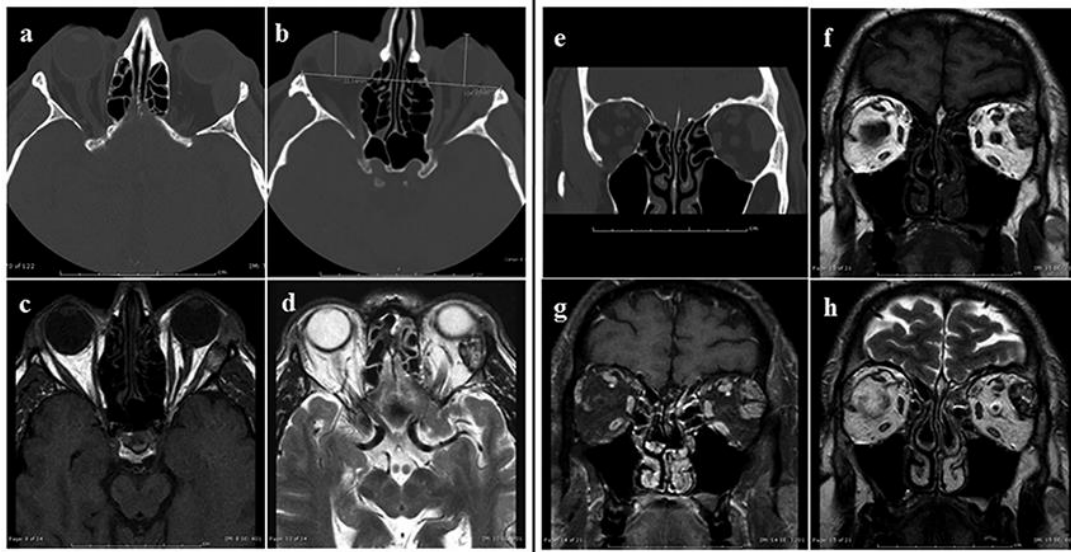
Images of a solid mass (acinic cell carcinoma) within the left lacrimal gland. (a) Axial CT-scan images show an oval mass (2 × 2.5 cm) of heterogeneous density associated with the left lacrimal gland. There is a modest scalloping of the great wing of the left sphenoid bone. (b) CT-scan in axial view. The interzygomatic line was used as a reference for measuring the exophthalmos. 22.14 mm in right eye versus 25.65 mm in left one. Exophthalmos amounts of 3.51 mm. (c) T1-weighted spin-echo MR imaging of the tumor. The contour of the lesion is evident, as well as the separation between the mass and the extraocular muscle, the rectus lateralis muscle. (d) T2-weighted turbo spin-echo MR imaging shows an oval well defined mass in the superolateral extraocular compartment of the left orbit within lacrimal fossa; it is in contact with the postero-superior outline of the ocular globe. (e) coronal CT-scan images show an oval mass of heterogeneous density associated with the lacrimal gland. (f) T1-weighted spin-echo coronal MR imaging of the tumor. The outline of the lesion is evident; the density of the mass is not homogenous. (g) T1-weighted contrast-enhanced fat-suppressed spin-echo MR imaging. The tumor is well limited and presents a mild contrast-enhancement. (h) T2-weighted turbo spin-echo MR imaging. The tumor has well-defined borders and irregular density in the superolateral extraocular compartment of the left orbit within lacrimal fossa.
